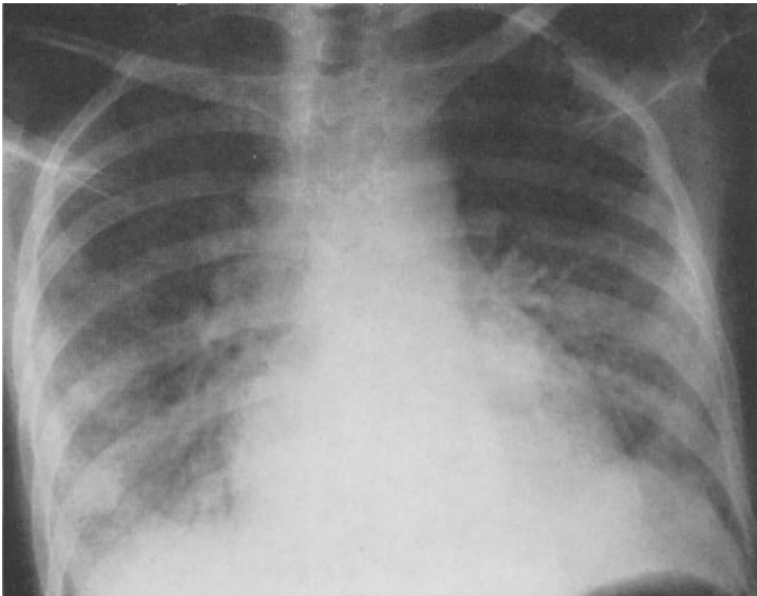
Chest roentgenogram of pneumonitis due to pneumocystis carinii several months following renal transplantation. Pathological examination revealed hyalin proteinosis and intraalveolar hemorrhage
